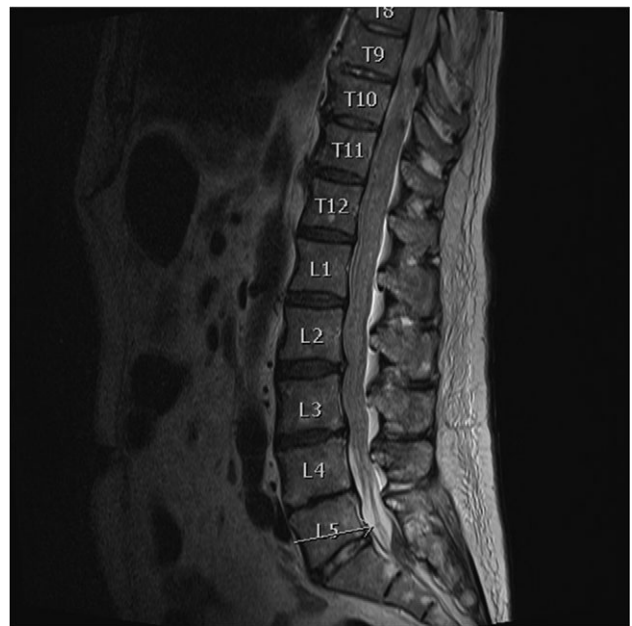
MRI spine T2 pre contrast. Arrow indicates possible nodular deposit at the level of L5.
